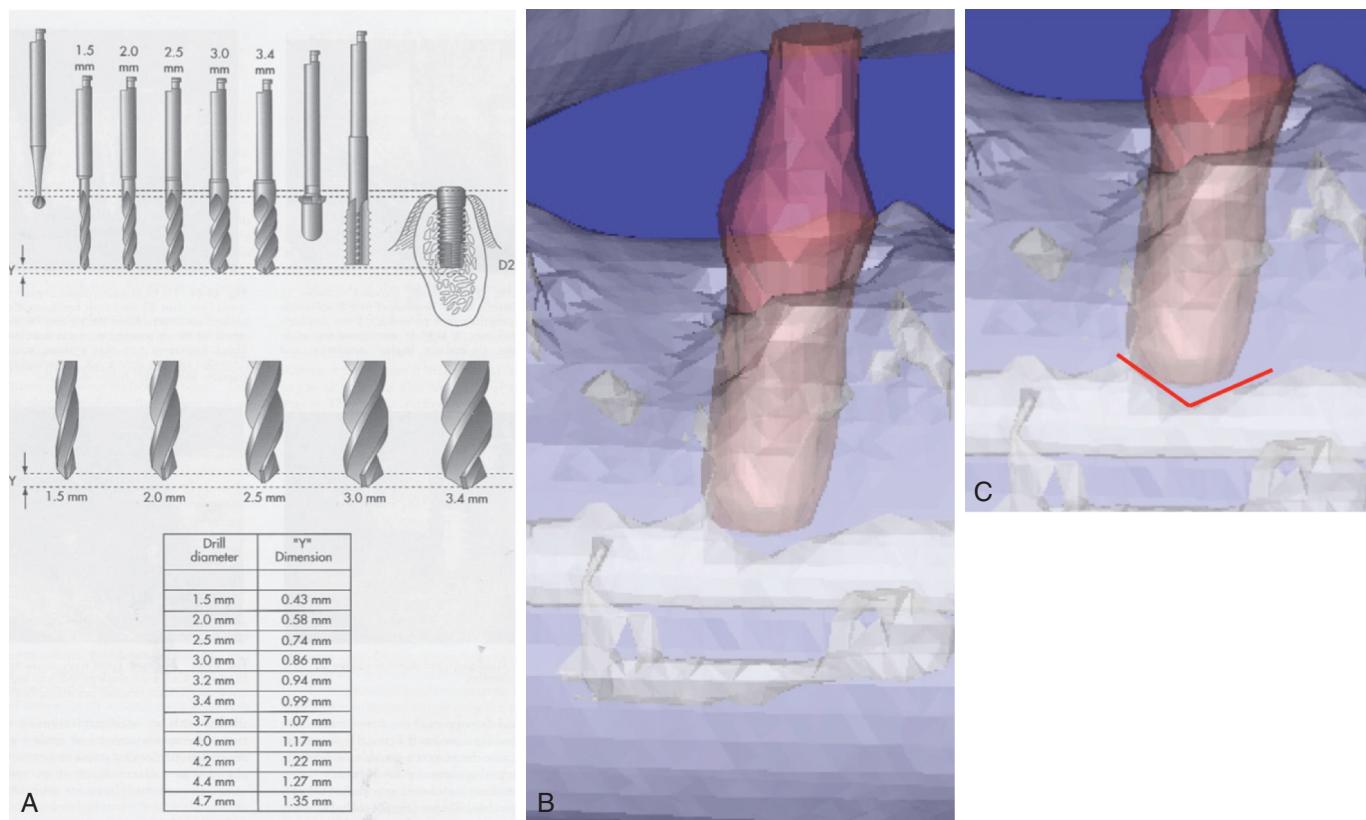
(A) Ideally, measure all burs before performing osteotomy. (B) "Y" diameter of surgical burs. (C) CBCT image showing penetration from "Y" dimension into mandibular canal. (A, From Misch CE, editor: *Contemporary implant dentistry*, St. Louis, 2008, Mosby.)
